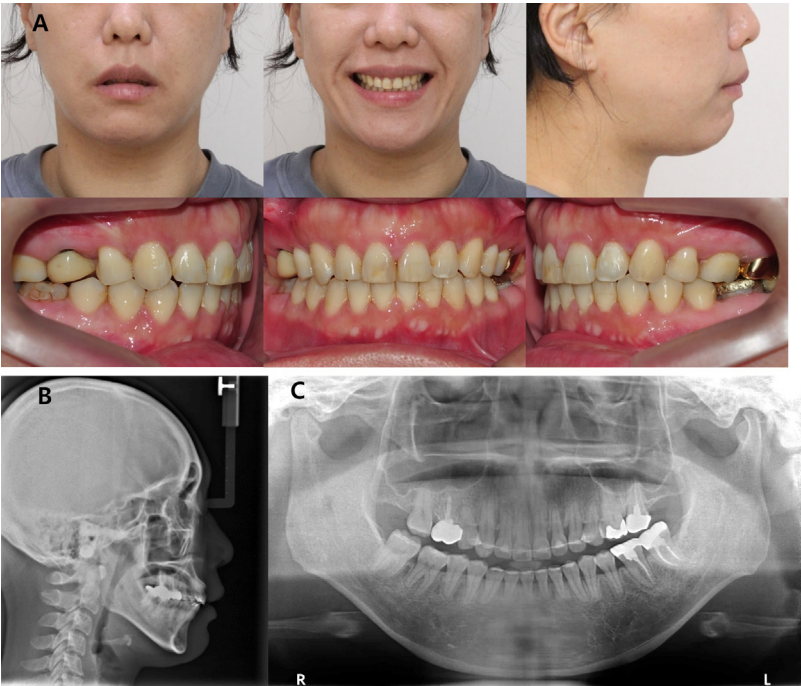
Case 1. Posttreatment data. A: Facial and intraoral photographs, B: Lateral cephalogram, C: Panoramic radiograph.
